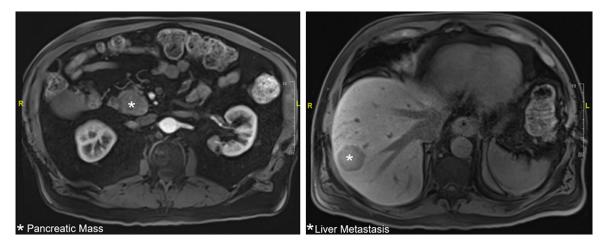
4.6 cm mass (asterisk) in the pancreatic head (*left*) and multiple heterogeneous lesions (asterisk) in the liver consistent with liver metastases on magnetic resonance imaging (MRI).
